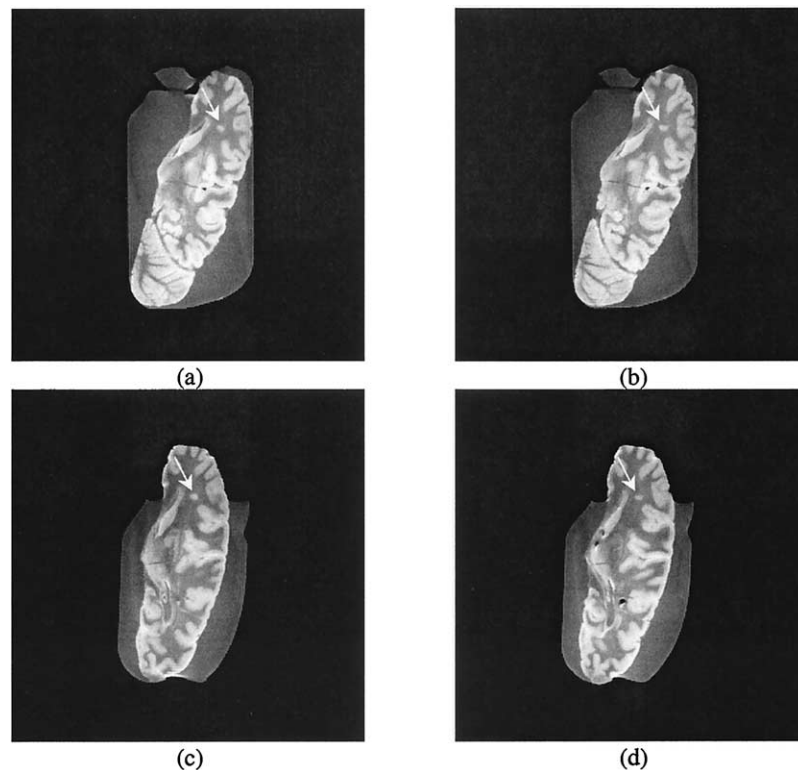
(a,b) MRI slices of the first scan of the in vitro half brain into which the analyzed lesion (white arrow) was extended. (c,d) The same lesion in the MRI slices obtained by scanning the in vitro half brain on a different day without making any effort in achieving precise repositioning.
